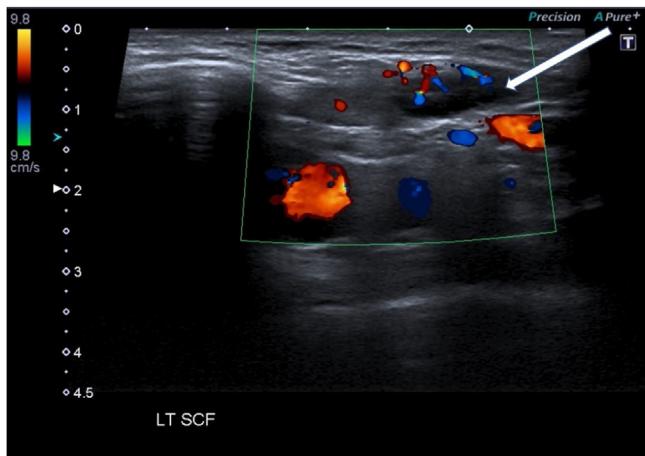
Reactive left supraclavicular fossa node (white arrow) with colour flow Doppler confirming normal hilar vascularity. Blood flow through the subclavian artery can be seen deep to the lymph node.
